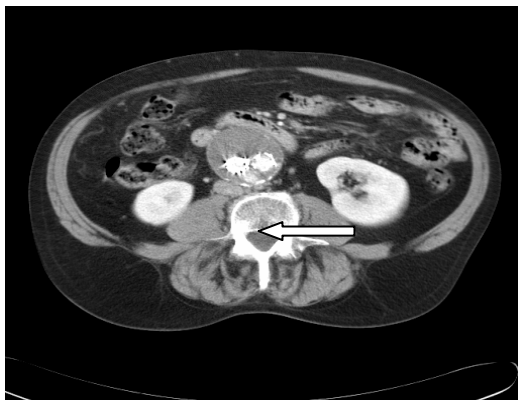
Endoleak not detected on Duplex: this CT scan was done 13 months post EVAR. There is a peri-graft endoleak posterior to the bifurcation (arrow) without increase in aneurysm size. Interestingly, this finding was also present on CT scan 6 months earlier, also not detected by Duplex. Possible explanation is that ultrasound waves hit the metal stent and is reflected back, that's to say cannot penetrate through the metal stent to examine what resides behind it.
